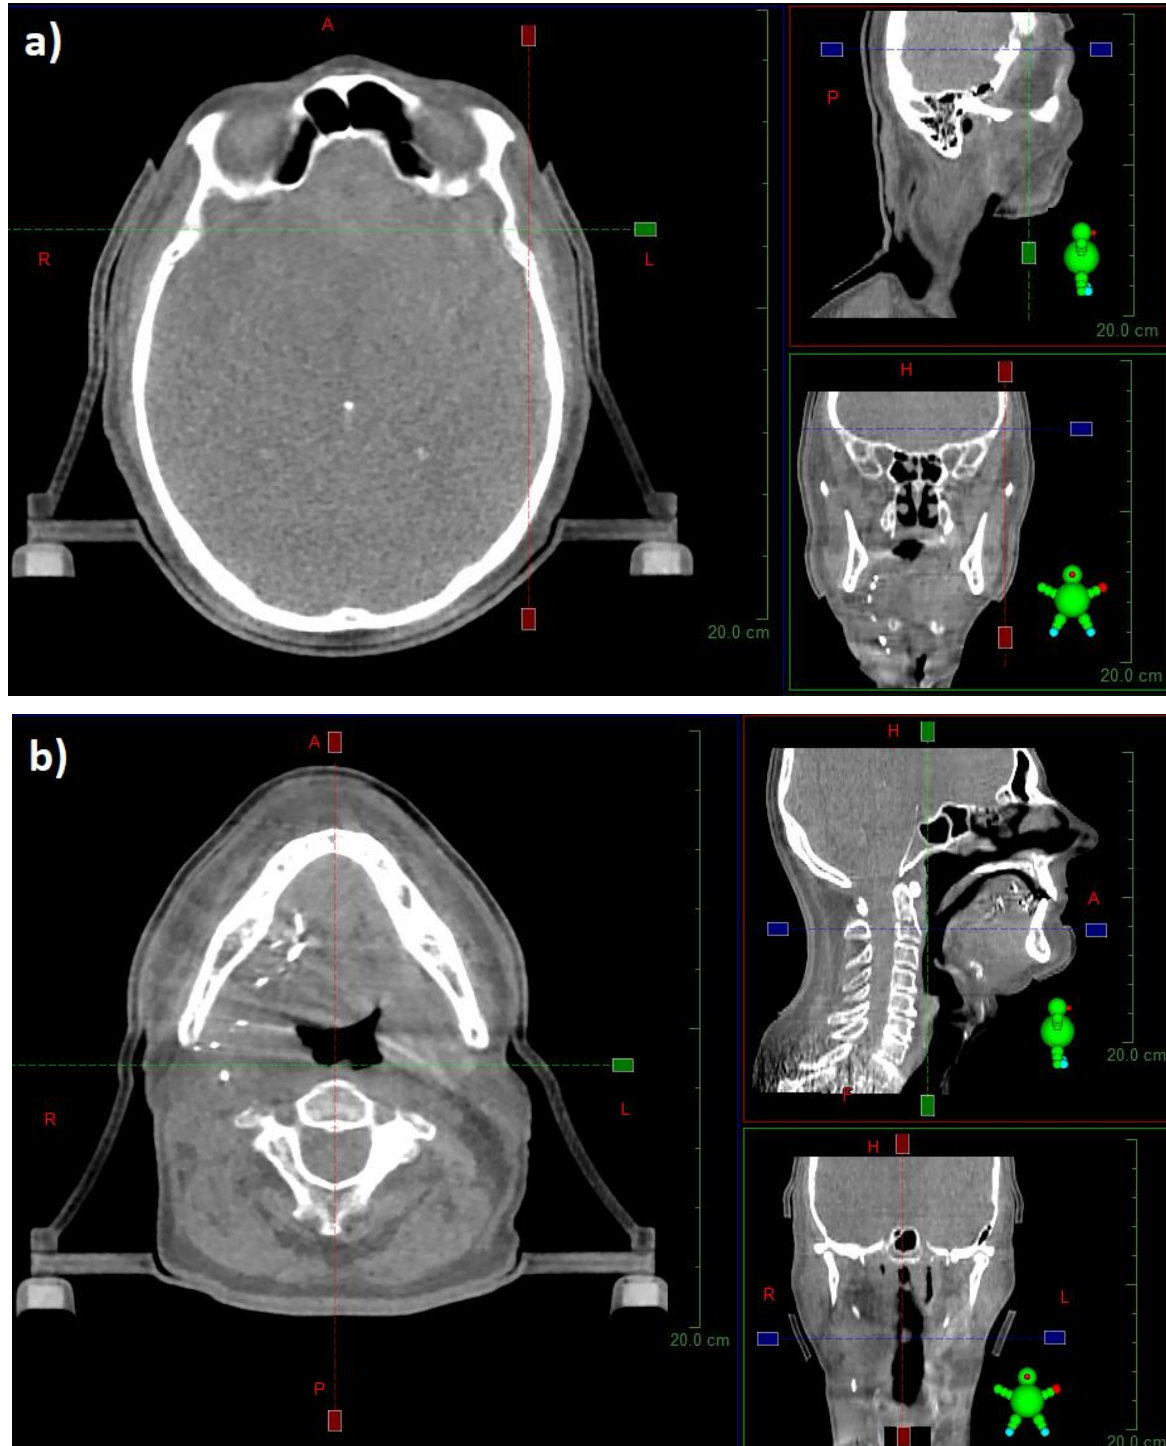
Visualization of the last study CBCT, i.e. in the seventh of seven weeks of treatment, for patient B immobilized with a 3D printed immobilization. The visualized regions are the temporal bone region (a) and the mandible region (b). The study patient is the patient for which the QA of the 3D printed immobilization is shown in Figure 4.
